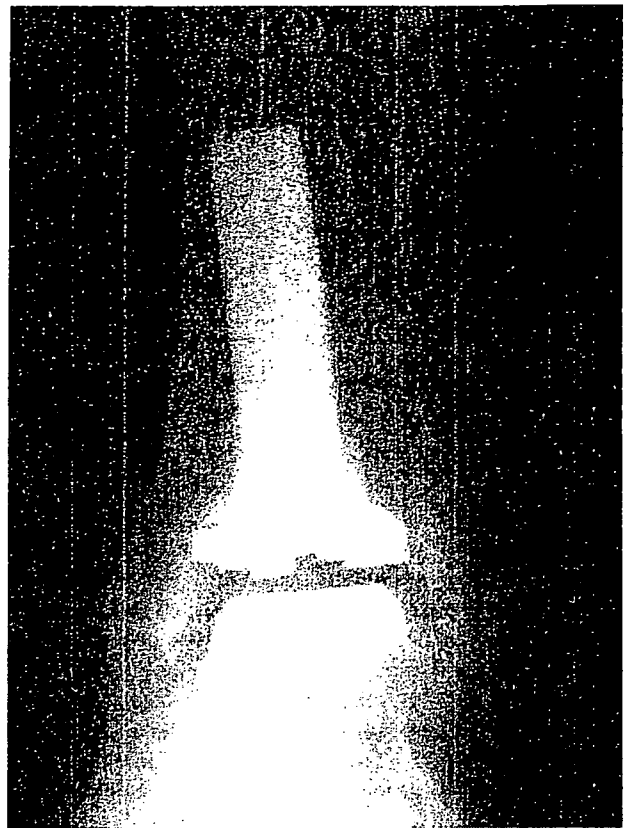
AP radiograph demonstrating a clear zone between HA and the tibial component. In this case, a clear zone between HA and the tibial component was obvious, whereas no clear zone was recognized between HA and bone or between bone and the tibial component.
